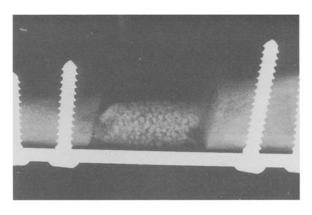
X-radiograph control of the active reactor after implantation.
